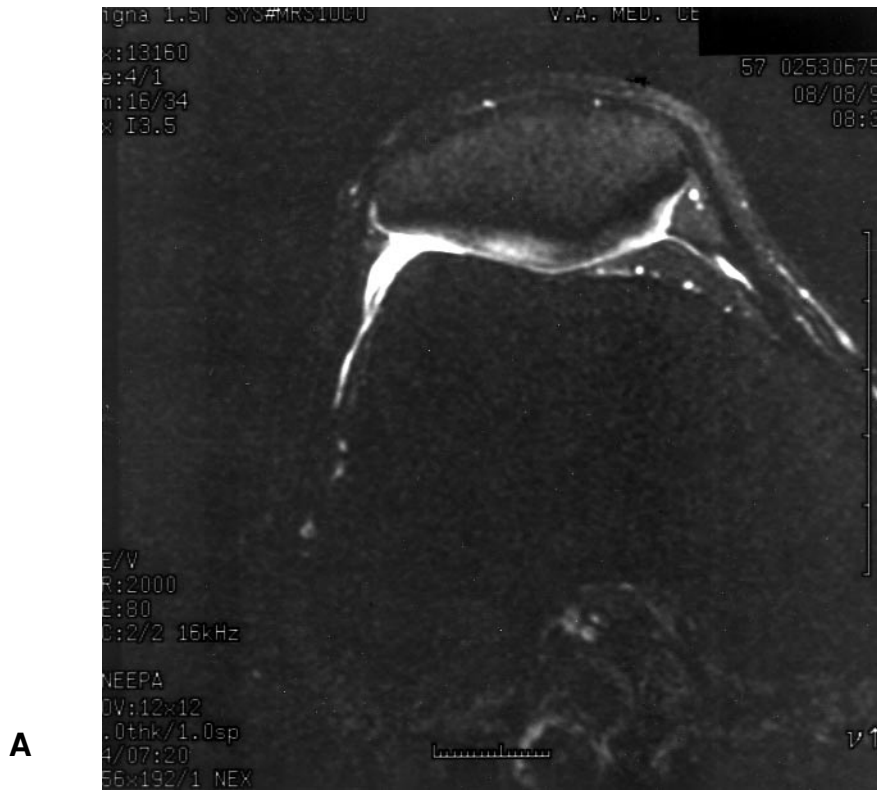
Axial T2 weighted MR images of (A) small effusion (grade 1), (B) moderate effusion (grade 2), and (C) large effusion (grade 3).
